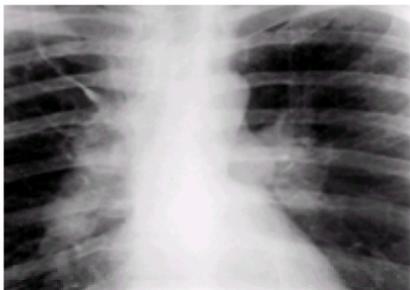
Bilateral hilar lymphadenopathy due to sarcoidosis may be discovered on routine chest radiographs in asymptomatic individuals. It also frequently presents in acute sarcoidosis with fever, erythema nodosum, and arthritis.
